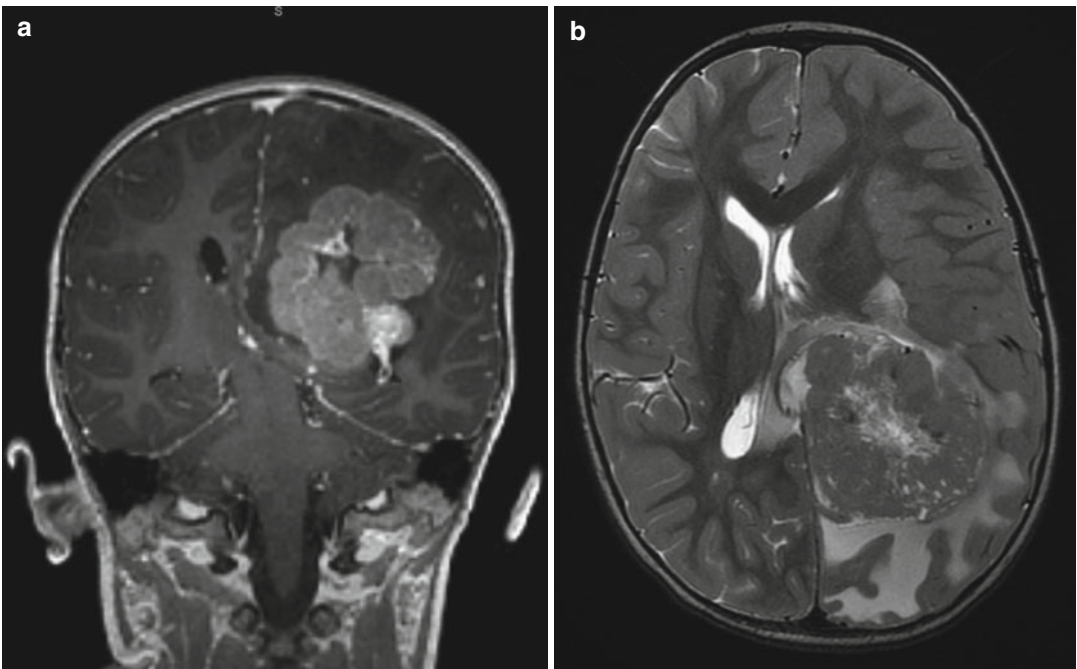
A large choroid plexus papilloma. (a) A sagittal precontrast T1-weighted MRI demonstrates a large lobulated mass within the lateral ventricle with associated
